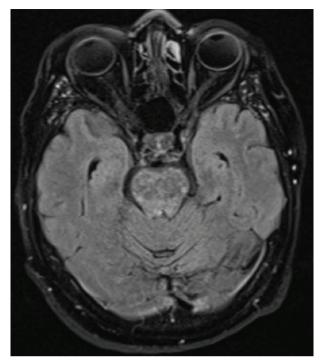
Magnetic resonance imaging, T2 sequence: cerebellum, hyperintense punctiform lesions.
